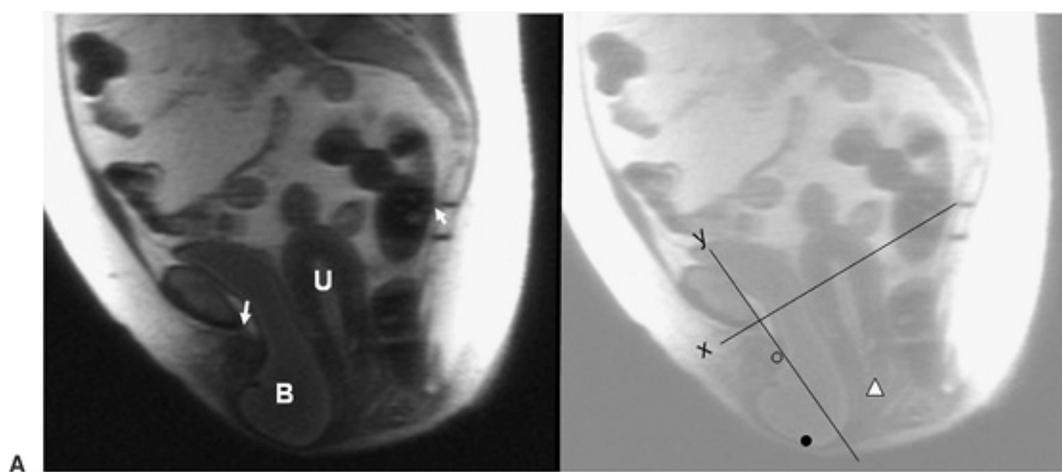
A (left): Valsalva MRI of a patient with anterior vaginal prolapse. (*U*, uterus; *B*, bladder, *arrows*, at sacrococcygeal joint and inferior pubic point for sacrococcygeal inferior pubic point [SCIPP] line). Right: System marking the most dependent portion of the bladder (*black dot*), uterine cervix (*triangle*), and urethra (*circle*). *X* axis follows SCIPP line and allows the locations of points to be determined and compared. B: The relationship between the magnitude of anterior compartment descent (caudal bladder point), and descent of the cervix below normal is displayed. (Based on Summers 2006. Copyright © DeLancey 2006.)
